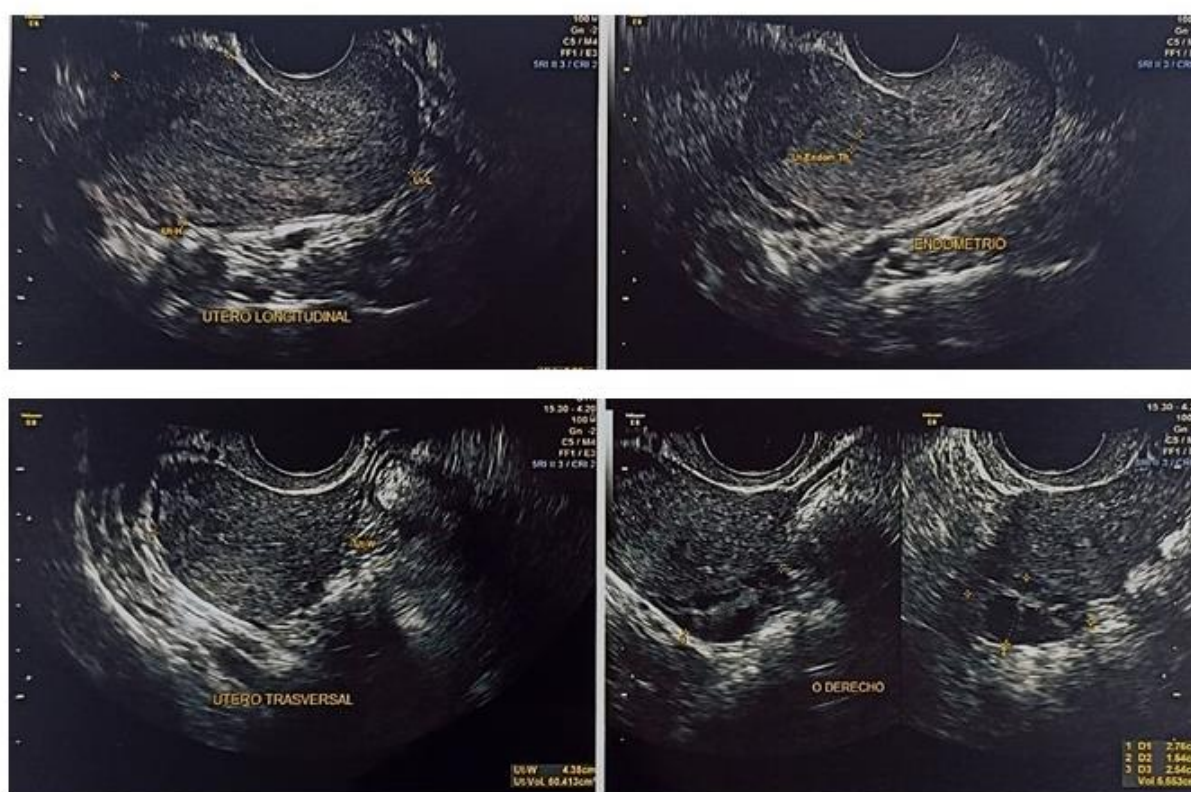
Transvaginal ultrasound images showing bilateral ovarian morphology. The left ovary measures 28x14x28 mm with a volume of 5.8 cc, and the right ovary measures 27x15x25 mm with a volume of 5.6 cc. Both exhibit a follicular pattern and cysts. Homogeneous stromal tissue is observed in both ovaries. The endometrium presents as a Type I, bilaminar, measuring 3.9 mm across both walls.
